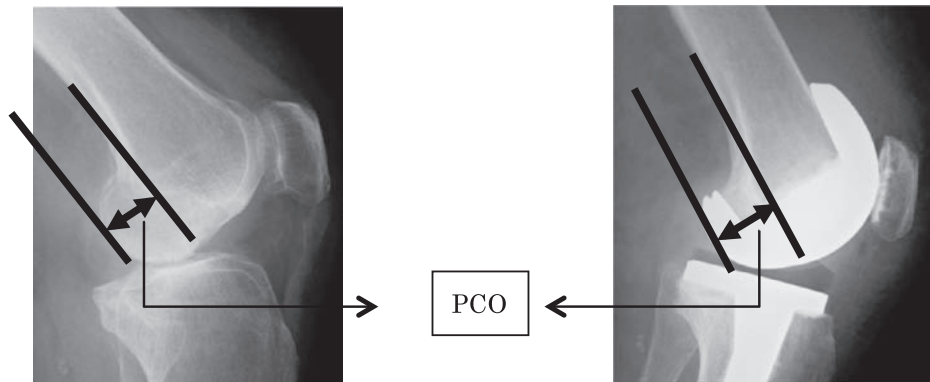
Posterior condylar offset (PCO) is the distance between the femoral bone cortex posterior to the bone axis and the most posterior margin of the condyle or femoral component in the lateral view on plain radiography.
